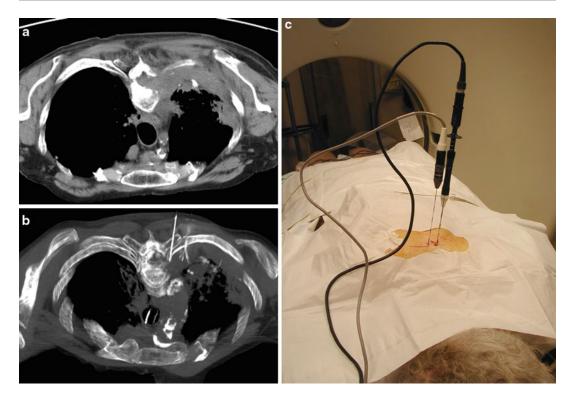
Metastatic colorectal carcinoma to rib, vertebral body, and pleural surface. (a) Prone CT demonstrates osteolytic destruction of the lateral portion of the vertebral body with associated soft tissue mass anterior to the rib. (b). Prone CT image shows the passive thermocouple probe placed near the vertebral body pedicle with the RF electrode deployed laterally in the metastatic lesion. Ablation was discontinued when the temperature at the passive thermocouple reached 40 °C. (c) Photograph of the RF
